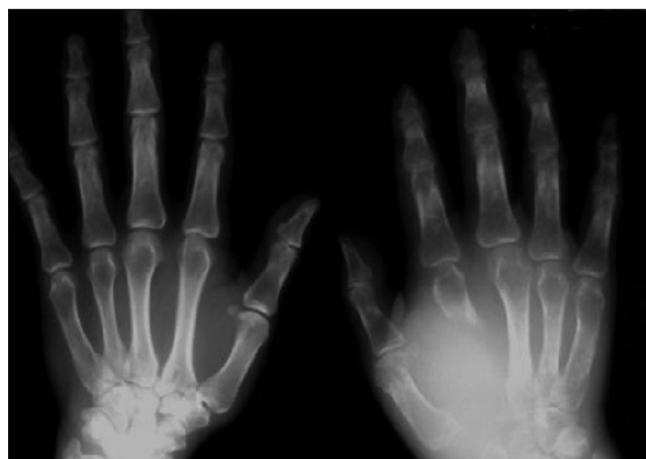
AP Radiograph of hands: Lytic destruction of 2nd metacarpal and distal carpal row on radial side of right hand
